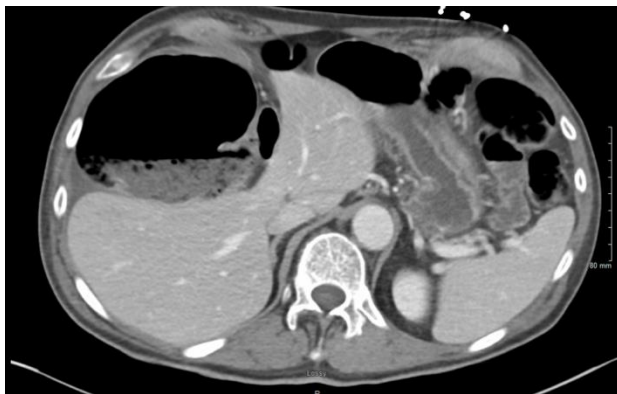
CT scan demonstrating cecal volvulus
